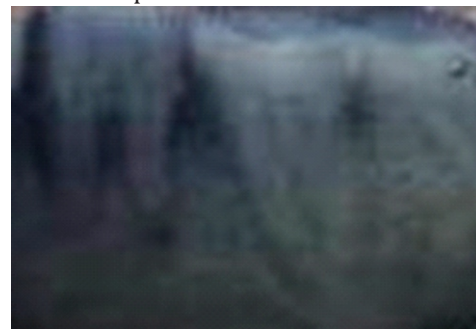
Periapical radiograph showing alveolar and furcation bone loss involving the right permanent mandibular first and second molars.
